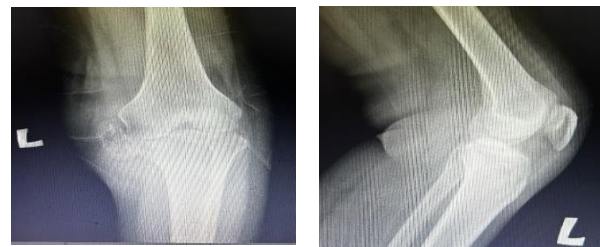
Radiograph of left knee post I&D and arthrotomy joint washout
